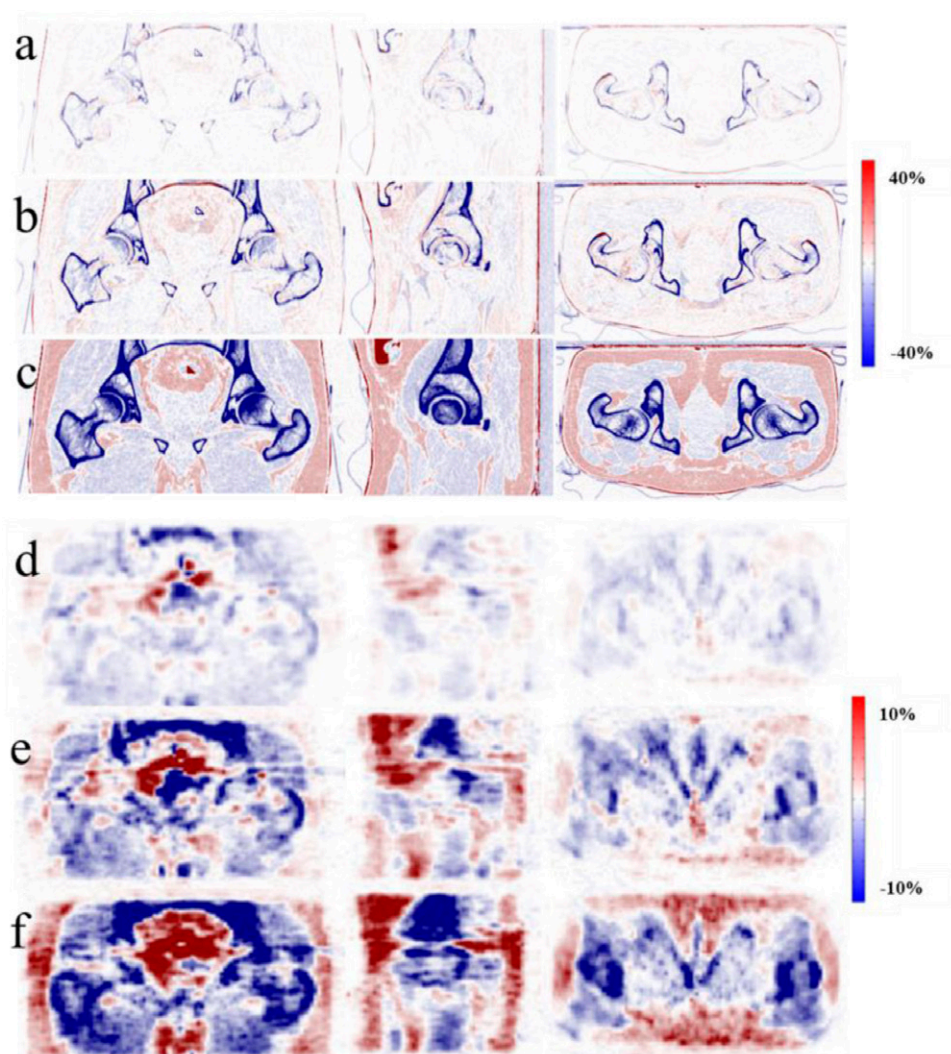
Representative slices of attenuation error maps for (a) LW; (b) MV; (c) water-only and SUV bias maps for (d) LW; (e) MV; (f) water-only methods.
